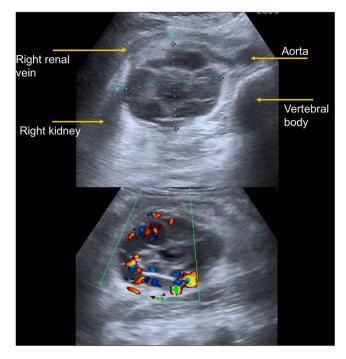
Ultrasound study, both in B and Color-Doppler modes.
